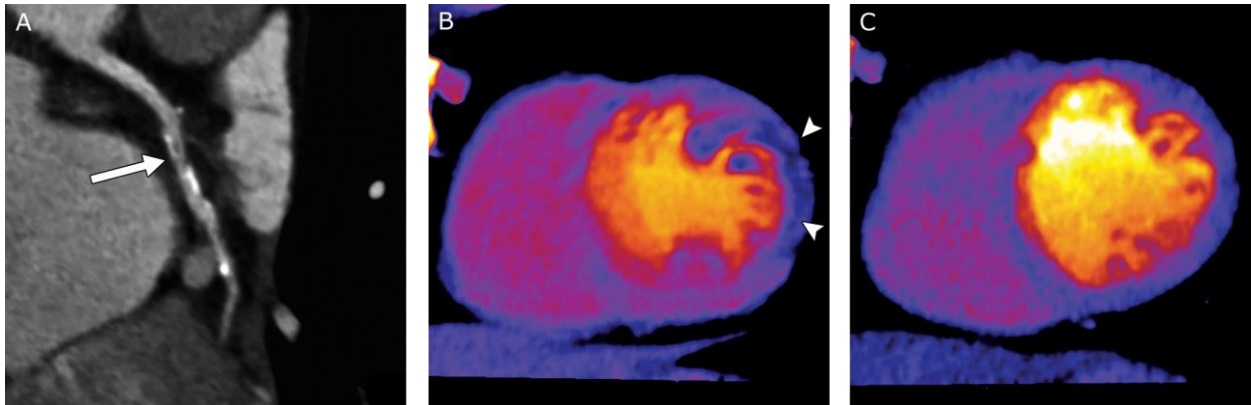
72-year-old man with multiple cardiovascular risk factors who presented with chest pain suggestive of ischemic heart disease and was referred for coronary CT angiography and myocardial perfusion imaging. The left circumflex artery shows mixed plaque with intermediate-to-severe stenosis (A). At stress, the iodine distribution map (B) shows well-demarcated area of decreased myocardial iodine content in lateral wall of left ventricle, which is reversible on rest image (C). Findings are thus consistent with lateral wall ischemia [14].
